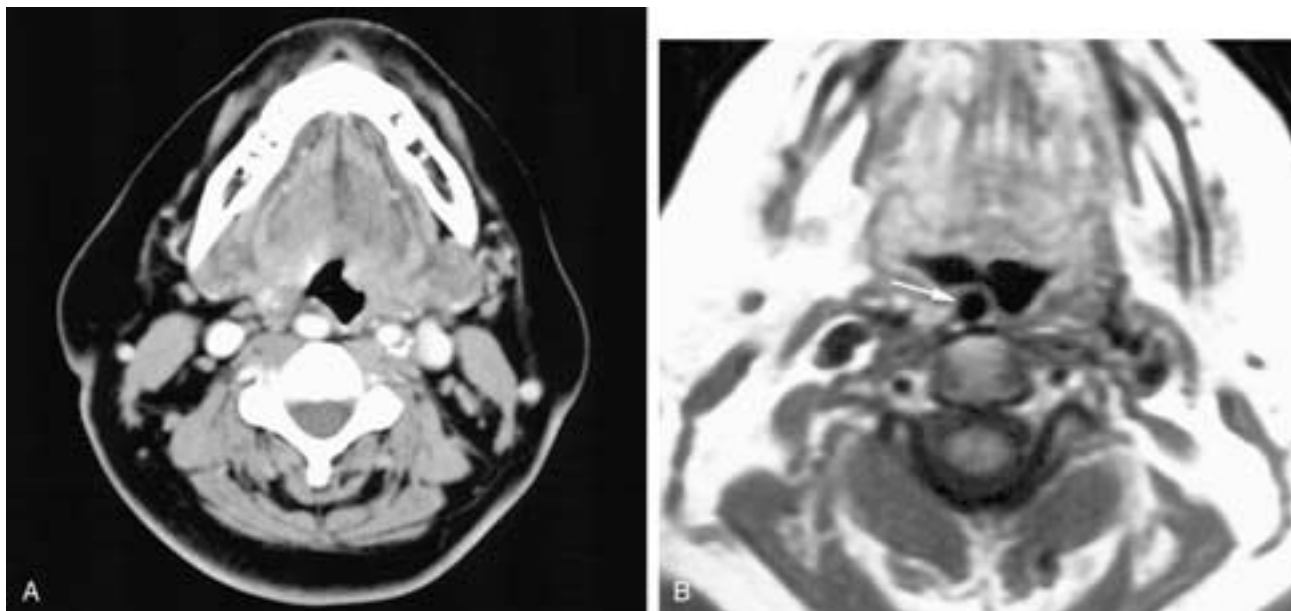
Axial contrast-enhanced CT scan (A) shows a normal variant, a medially displaced right carotid bulb indenting the posterior wall of the hypopharynx. The left carotid bulb, which has calcific atherosclerotic changes, is seen more laterally relative to the pharynx on the opposite side. Axial T1-weighted MR image of another patient (B) shows an almost midline-deviated right internal carotid artery (*arrow*). (Courtesy of Dr. David W. Johnson.)
